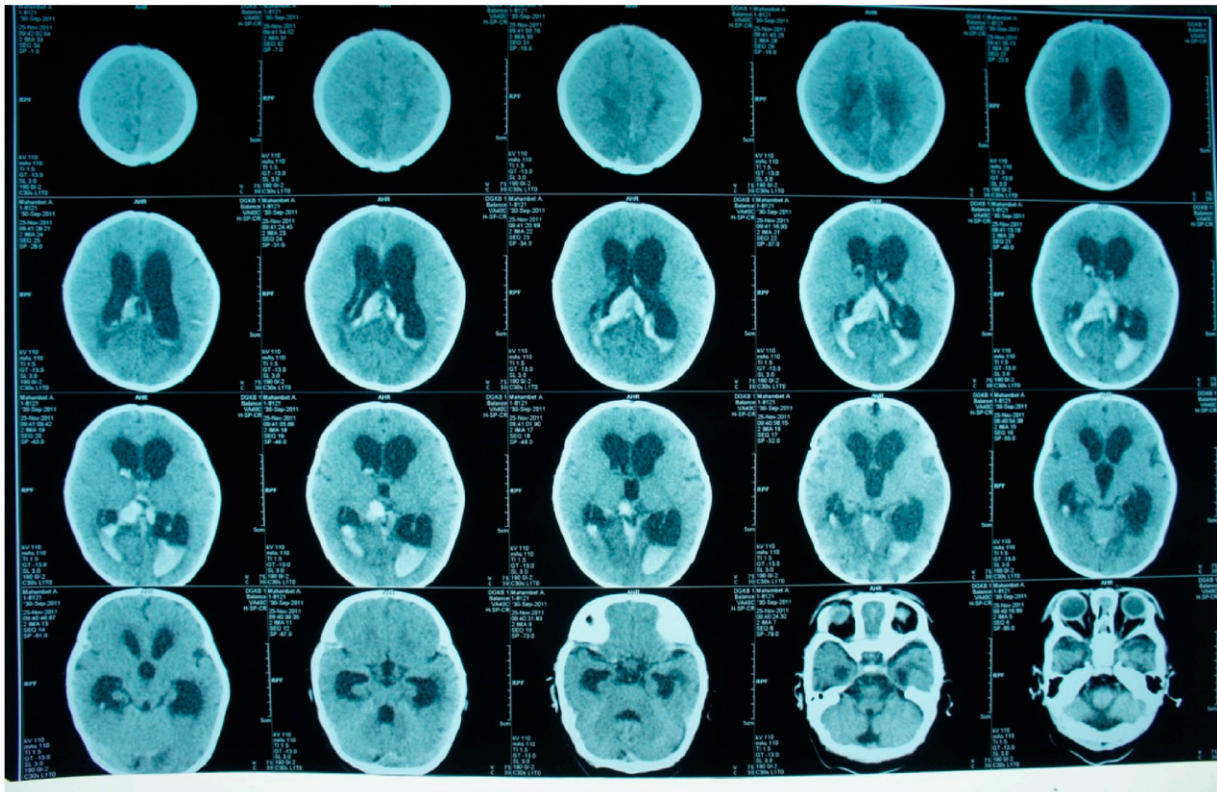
Computed tomogram of intraventricular hemorrhage.
